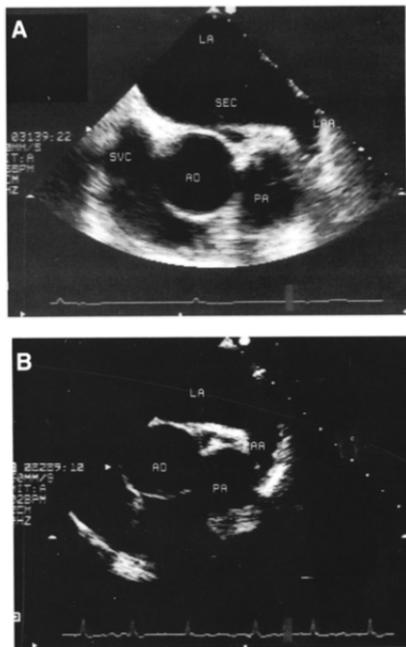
Transesophageal echocardiograms from patients with nonvalvular atrial fibrillation with (A) and without (B) left atrial spontaneous echo contrast (SEC). AO = aorta; LA = left atrium; LAA = left atrial appendage; PA = pulmonary artery; SVC = superior vena cava.
